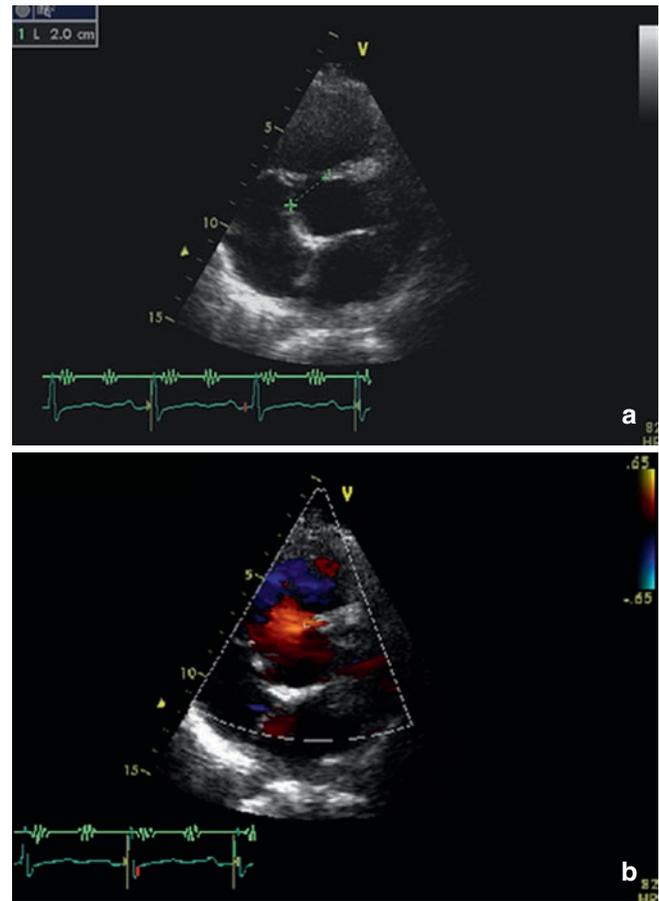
(a) Perimembranous VSD as shown on a parasternal short-axis view. Typically the VSD is adjacent to the septal leaflet of the tricuspid valve. (b) Perimembranous VSD colour Doppler image of left to right shunt
